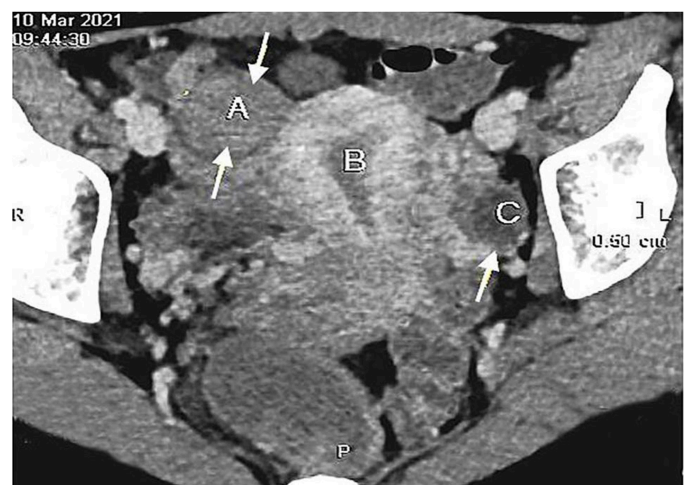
Computed tomography: A- small pelvis neoplasm; B- uterus; C- left ovary.
